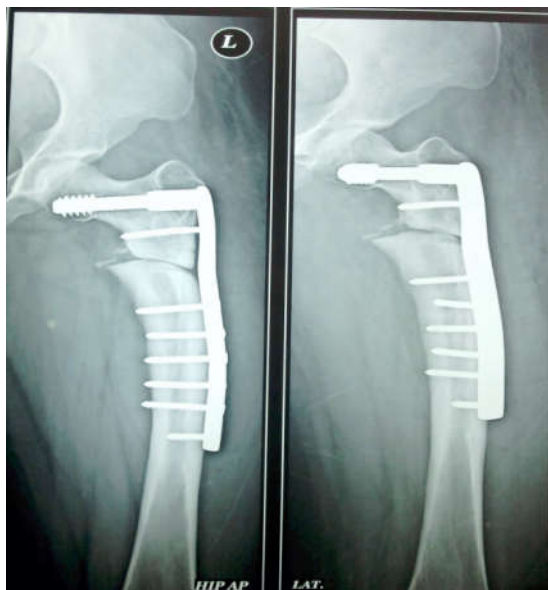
Post operative radiograph case 2
